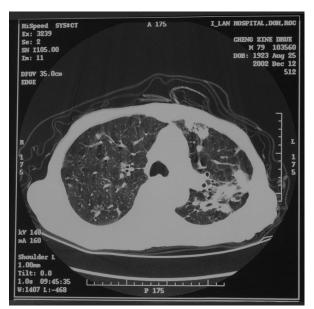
Thin section high-resolution CT at the carina level shows multiple ill-defined nodules in both upper lobes with more prominence in the left side. A small cavity was evident in the left upper lobe. Pulmonary tuberculosis was highly suggested.
